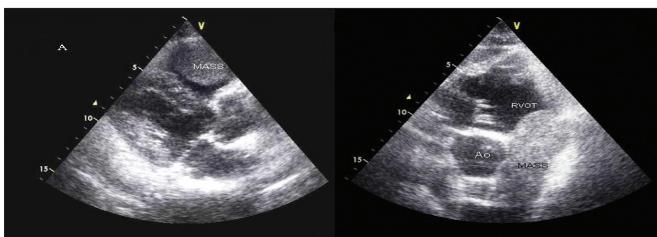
Two-dimensional echocardiogram, parasternal long-axis view showing the mass in the right ventricular outflow tract (panel A) and parasternal short-axis view showing the right ventricular mass, obstructing the outflow tract and impinging onto the pulmonary valve (panel B)
